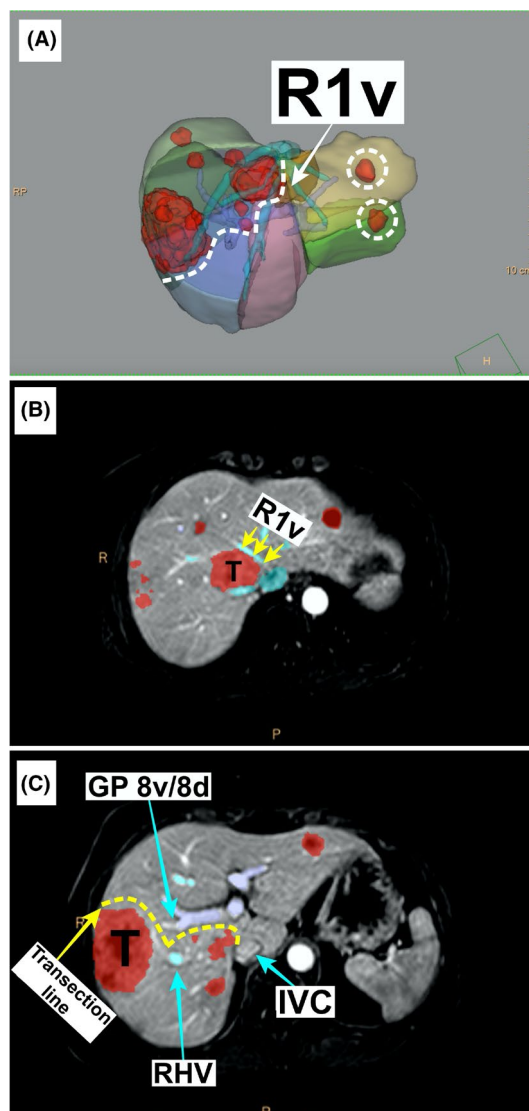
Liver CT mapping of patient S.'s metastatic lesions. A – 3D segmentation and volumetry with metastatic lesions mapping, parenchymal transection lines. B and C—CT data in the axial plane. R1v is the zone of vascular contact of one of the metastatic lesion in S8/S1. T—metastatic lesions. GP8v/8d—Glissonean pedicles for ventral and dorsal portions of S8, respectively. IVC, inferior vena cava. RHV, right hepatic vein
